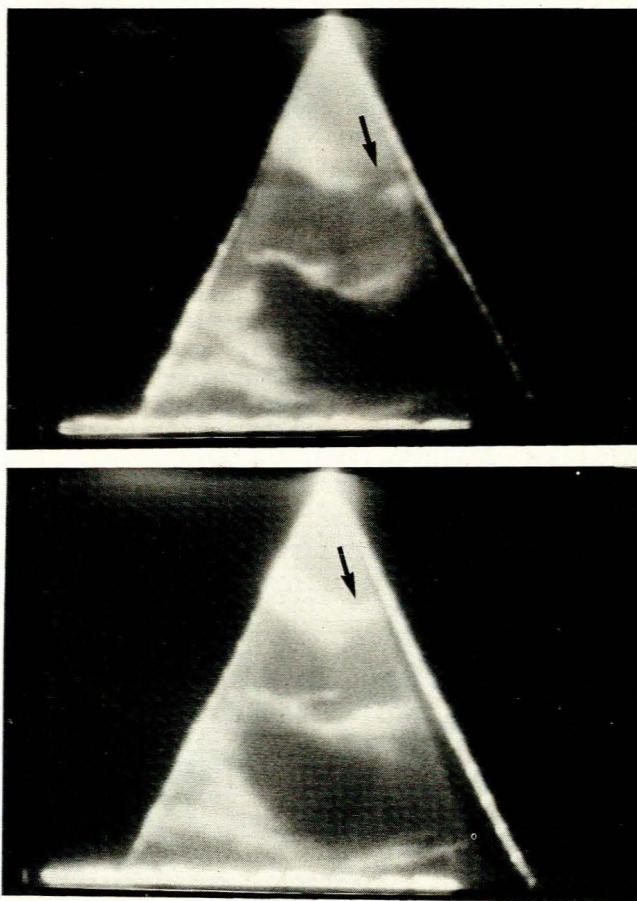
Pre-operative two-dimensional echocardiogram. Long-axis view shows fistula (arrowed) widely open in diastole (top), but much smaller in systole (bottom).
